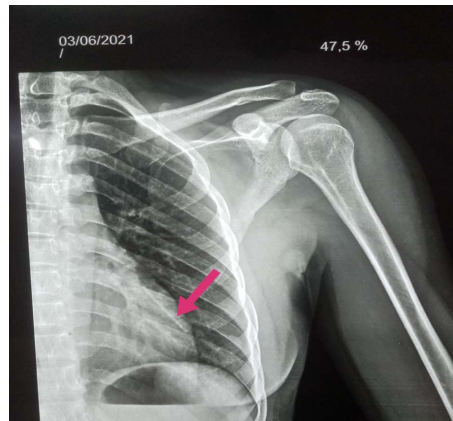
Chest X-ray from the front showing the implant in the left lung field.
